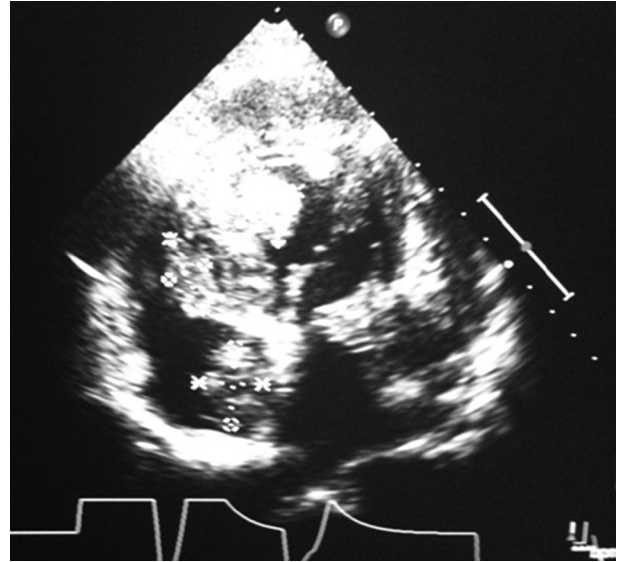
2D Echocardiogram showing multiple cardiac masses attached to the IVS.
